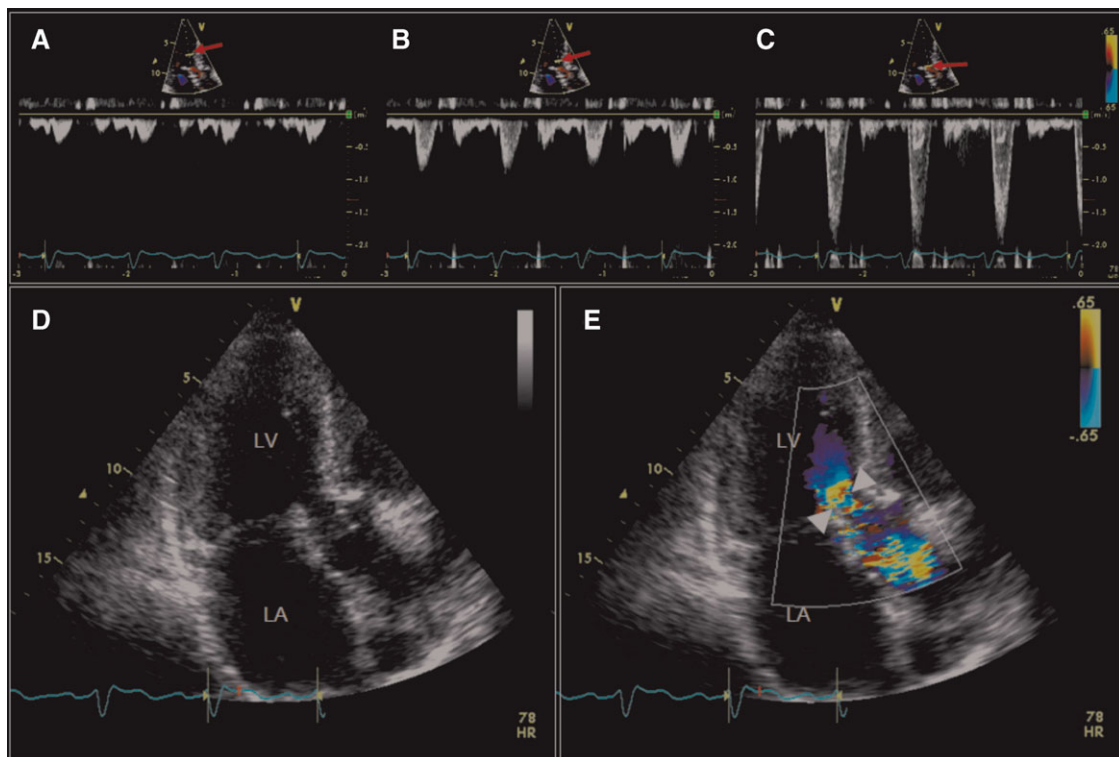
Pulsed wave Doppler tracing along the LVOT (A–C) points out the obstruction level with a high velocity profile (C)—no mid cavity of LV obstruction is demonstrated. A 2-D echo (D) with colour Doppler (E) shows flow acceleration with aliasing at the sub aortic level.
